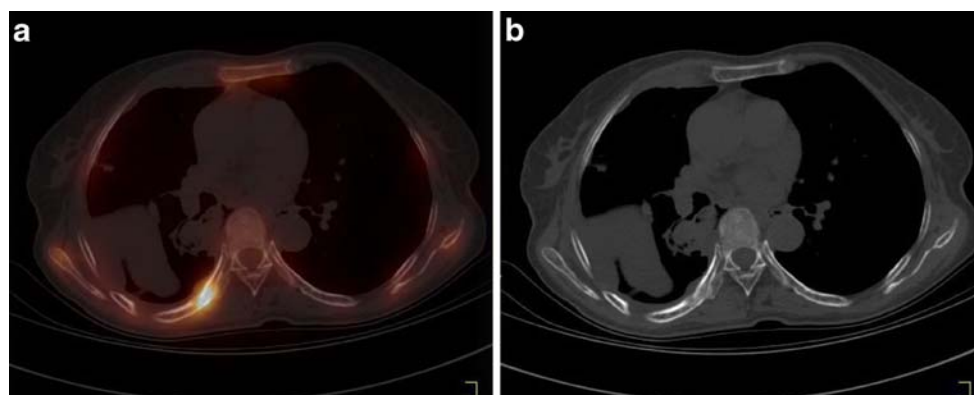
Images of a 66-year-old woman with lung cancer. a SPECT/CT fusion image showing the increased area of activity in the posterior part of the right seventh rib. b CT image showing destruction of the posterior part of the right seventh rib. The final diagnosis was bone metastasis. SPECT/CT sensitive for displaying increased tracer
